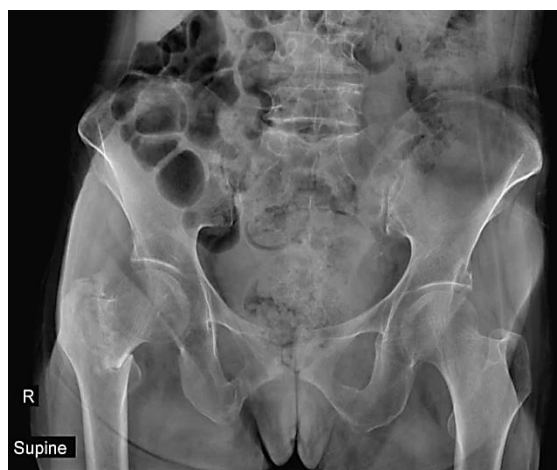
Case No. 3: the pelvic x-ray of the patient showing a right intertrochanteric fracture
